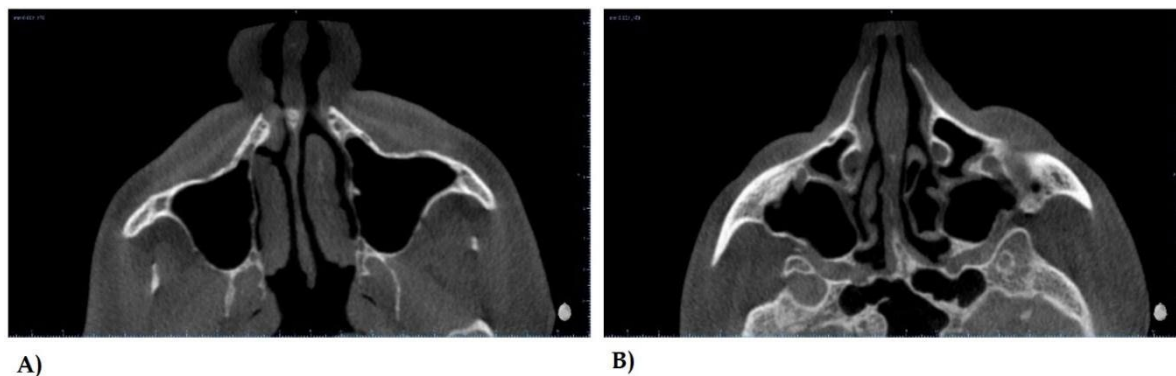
Conical Haz Computed Tomography observing nasal turbinate hypertrophy (A) and hypertrophy of the nasal septum (B)
